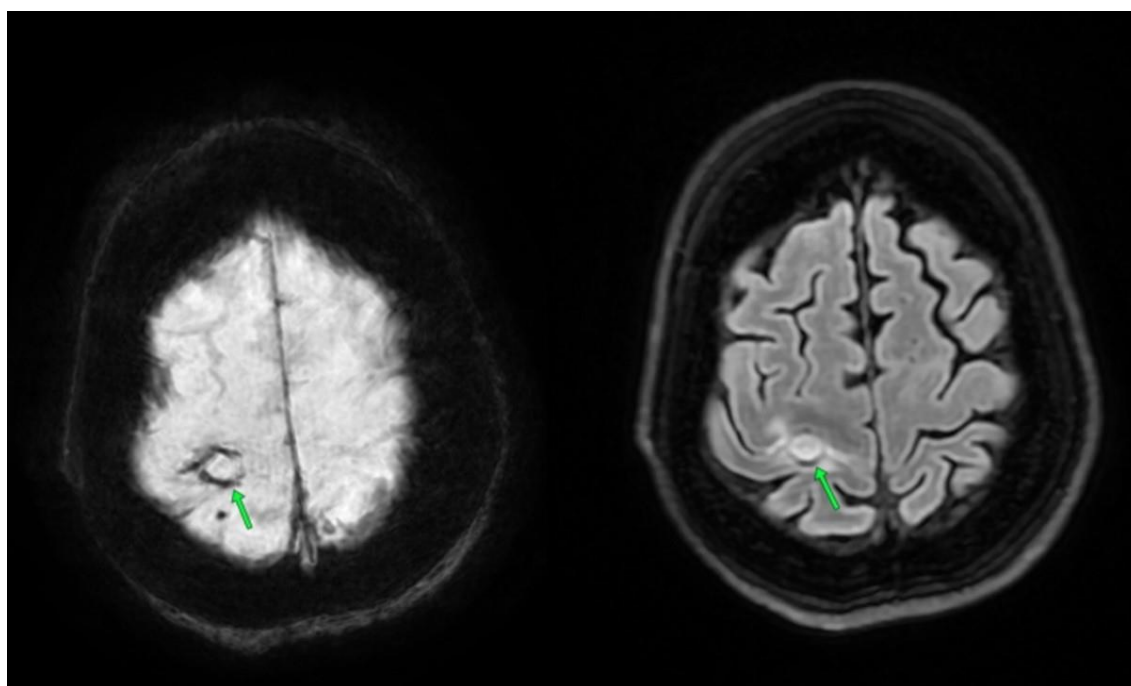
Right parietal lobe ICH, MRI SWI, T2 Flair, axial plane.
